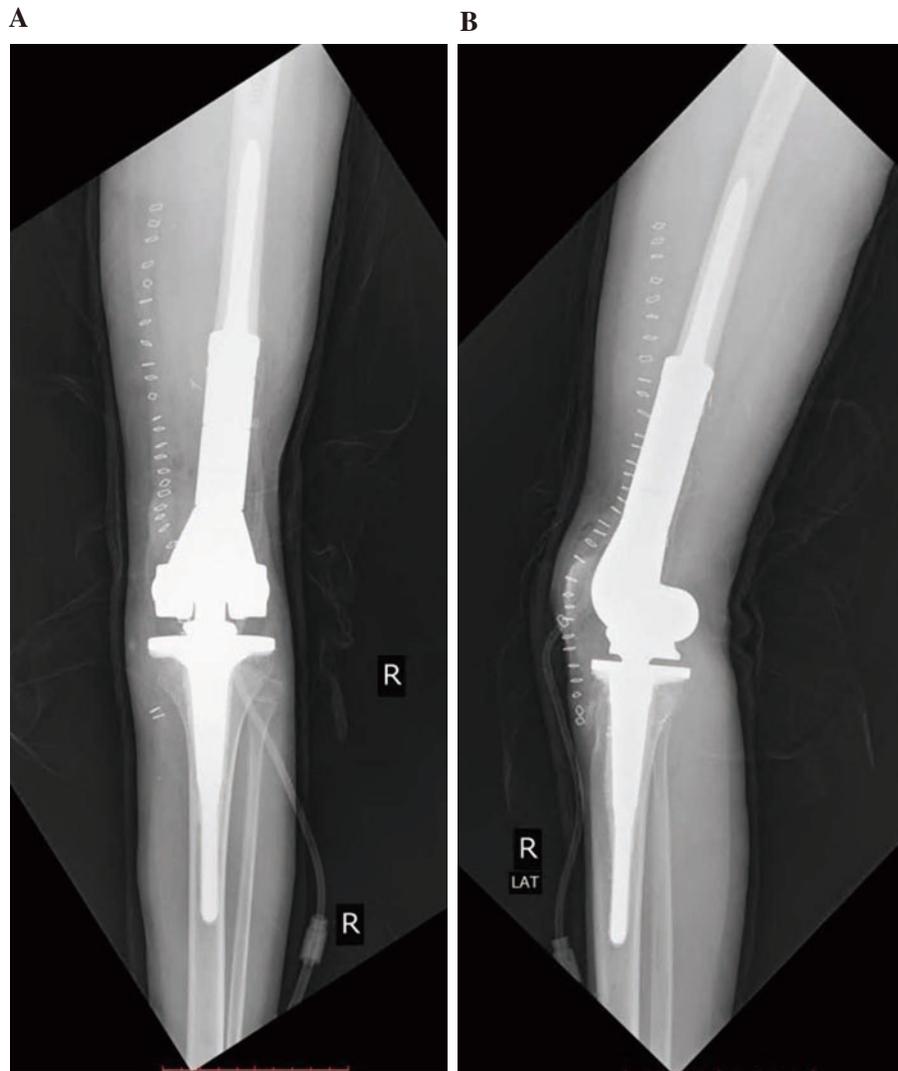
X-ray showing distal femur implant. A: Anteroposterior view of distal femur replacement with the hinge mechanism. B: Lateral view of a distal femoral implant with a tibial tray and stem.
